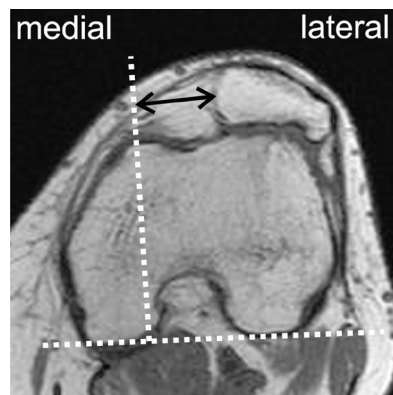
T1-weighted MRI in the axial plane, acquired in flexion, showing patella not fitting into the trochlea and with the medial margin lateralized in relation to a line perpendicular to the bicondylar line, in the plane of medial eminence of the femoral trochlea.
